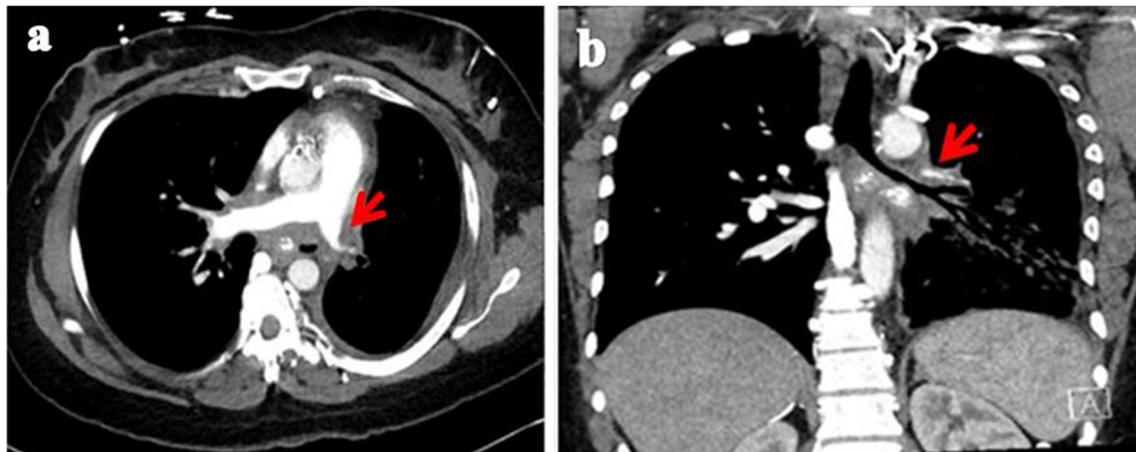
Axial (a) and coronal (b) soft tissue algorithm contrast-enhanced CT of the chest shows calcified lymph nodes and soft tissue encasing a severely narrowed left main pulmonary artery (solid arrow). Also noted are extensive groundglass infiltration of the left lung and milder groundglass infiltrates in the right upper lobe (not pictured). The constellation of imaging findings and reported surgical biopsy in 2009 that was
